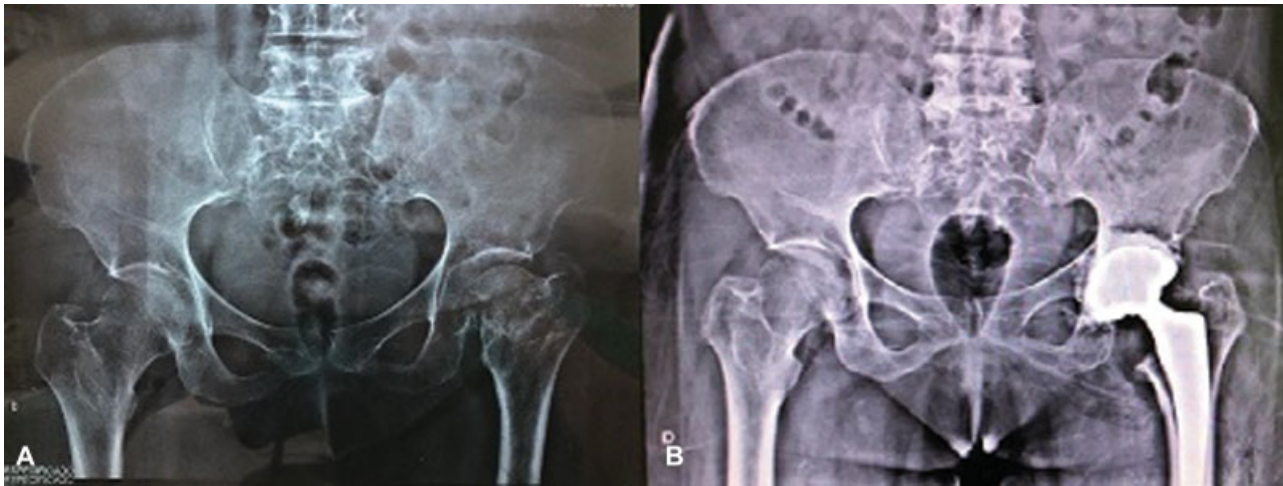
Preoperative anteroposterior pelvic radiograph of a 69-year-old female with femoral neck pseudarthrosis (A), and postoperative cemented DMC (B).
